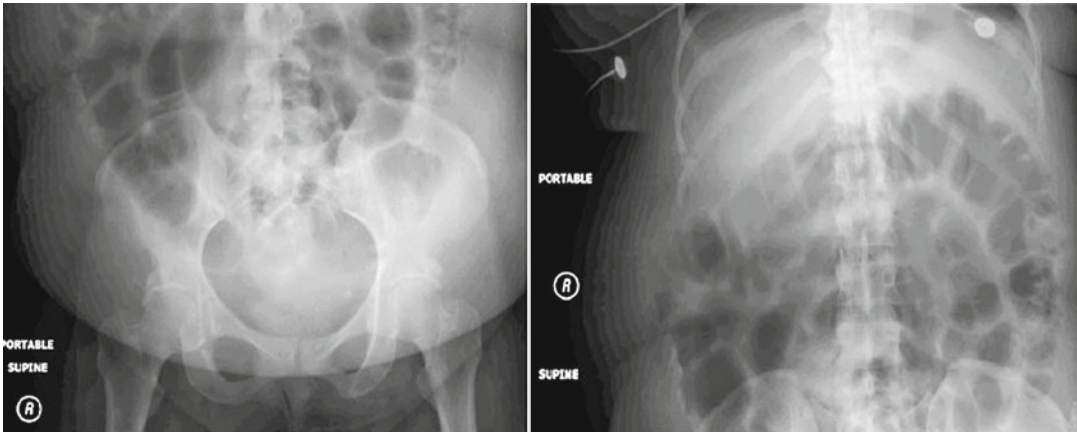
Abdominal X-ray demonstrating several dilated loops of small and large bowel representing an ileus
